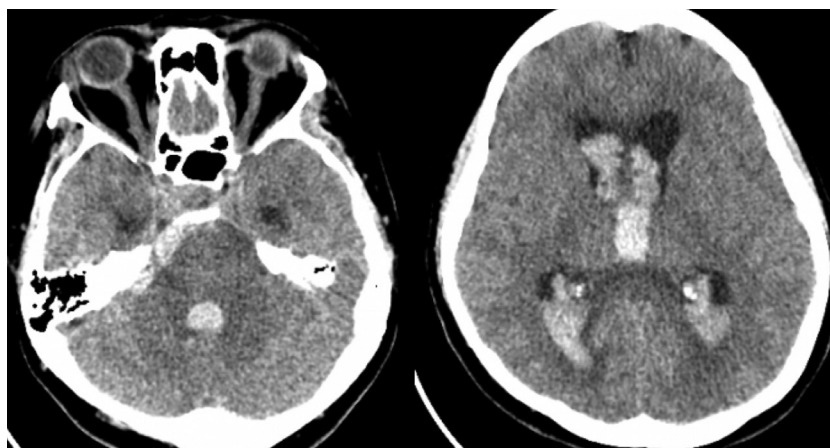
Head computed tomography at 21 days after COVID-19 onset (day 21) showing subarachnoid hemorrhage with intraventricular hematomas and ventriculomegaly.
